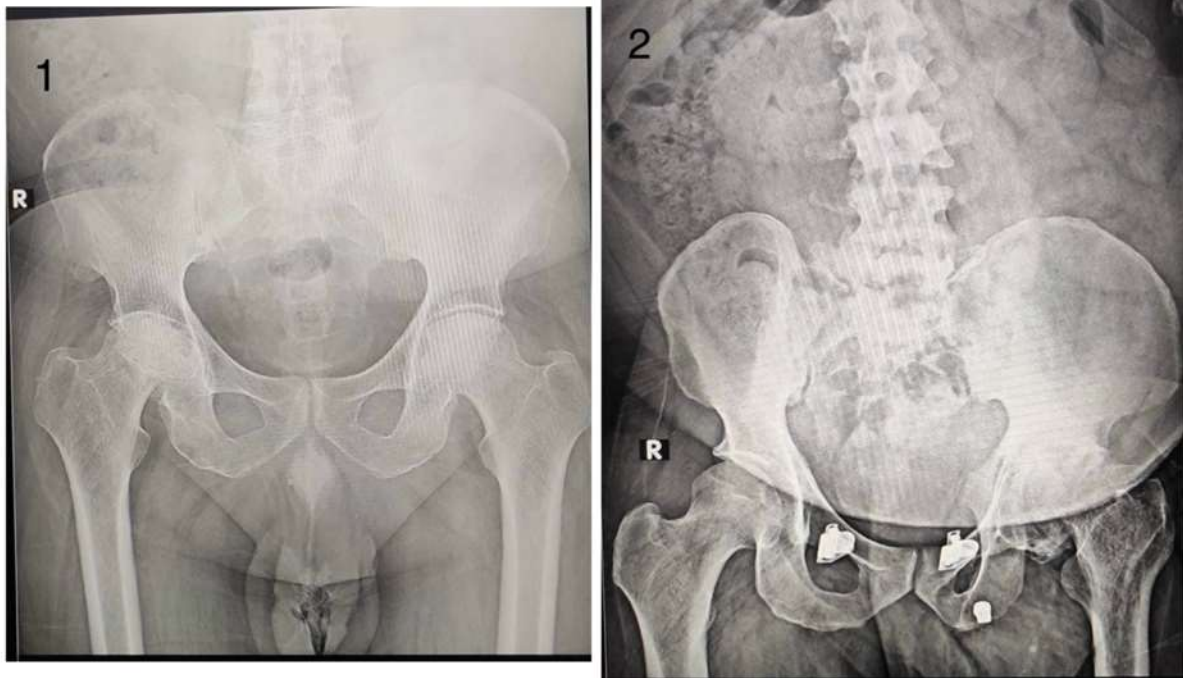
Plain X-ray of pelvis with both hip joints of a 51 year old male having stage 4 AVN of hip, involving the right side.
